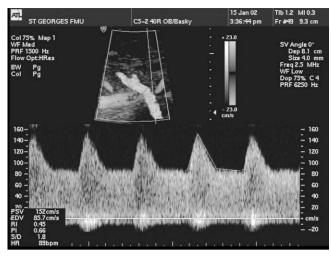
Normal uterine artery Doppler. Note the adequate diastolic flow. There is no diastolic notch.
